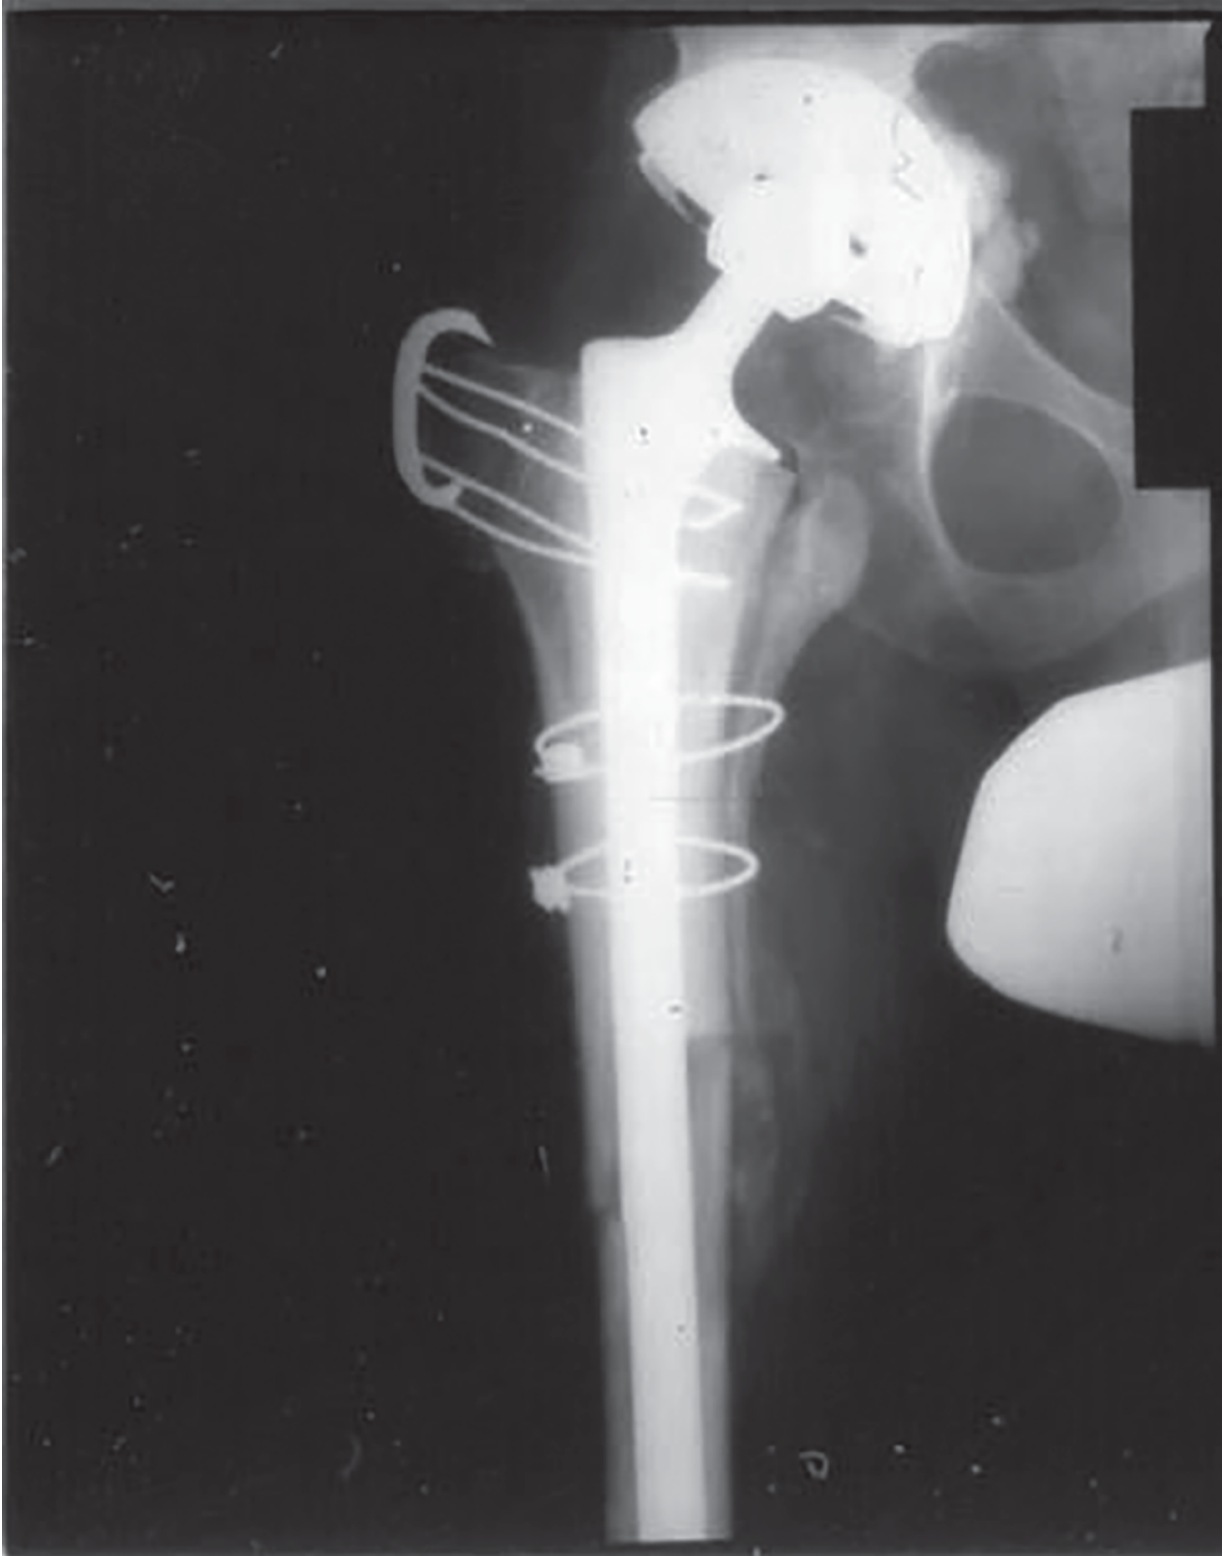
Postoperative AP radiograph of the proximal femur showing a long-stemmed implant cemented into a proximal femoral allograft. Note the step-cut junction to enhance junction stability.
